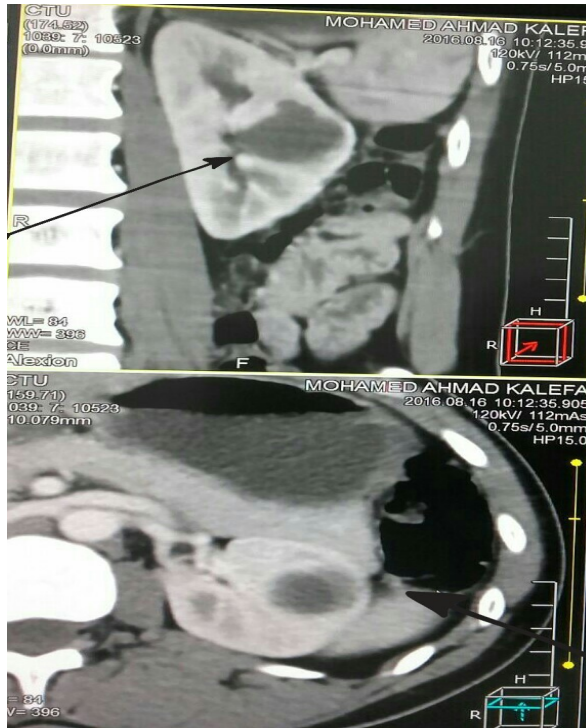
CT abdomen axial and sagittal for Patient 40 years old .(has Lft kidney cyst (black arrow
